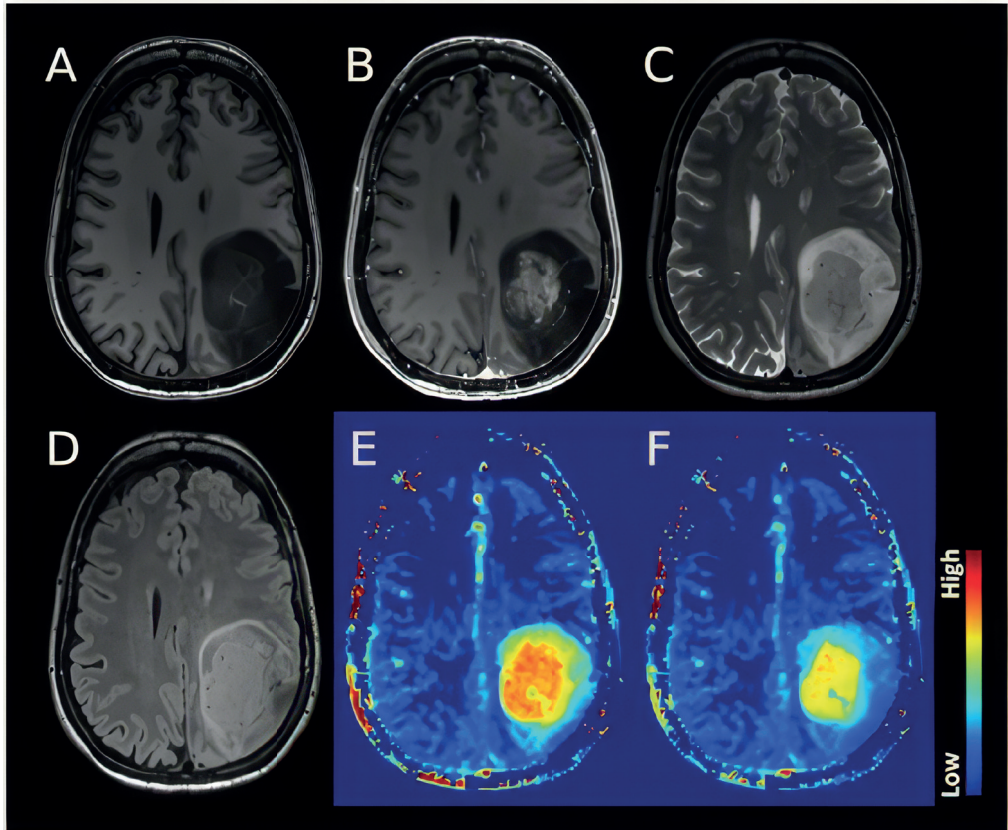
Example of an astrocytoma, IDH-mutant, 1p/19q retained, CNS WHO grade 4. The structural images (A: T_1w , B: T_1w post-Gd, C: T_2w , D: FLAIR) demonstrate a heterogeneous lesion with a rather solid central and well-enhancing part and a peripheral compartment demonstrating some T_2 /FLAIR mismatch without overt enhancement. The APT-weighted maps (E: standard APT CEST, F: fluid-suppressed APT CEST (Casagrande S et al. ISMRM 29th An Meet 2021)) show significantly elevated signal in the enhancing tumor, suggesting clearly high-grade features. Notably, the rim zone of the lesion shows variable degrees of APTw signal elevation in the fluid-suppressed images, thus suggesting that this compartment features mixed solid and cystic parts. Interestingly, the anterior rim zone, along with a halo surrounding the enhancing area, demonstrate a mildly elevated APTw signal that indicates likely high-grade metabolic tumor characteristics. The data were acquired on a Siemens 3T Prisma scanner. APTw protocol included $DC=91\%$, $B_1rms=2\mu T$, $Tsat=2s$, and WASAB1 for B_0 correction. WASAB1 and APTw data were processed in Olea Sphere 3.0 software (Olea Medical, La Ciotat, France).
